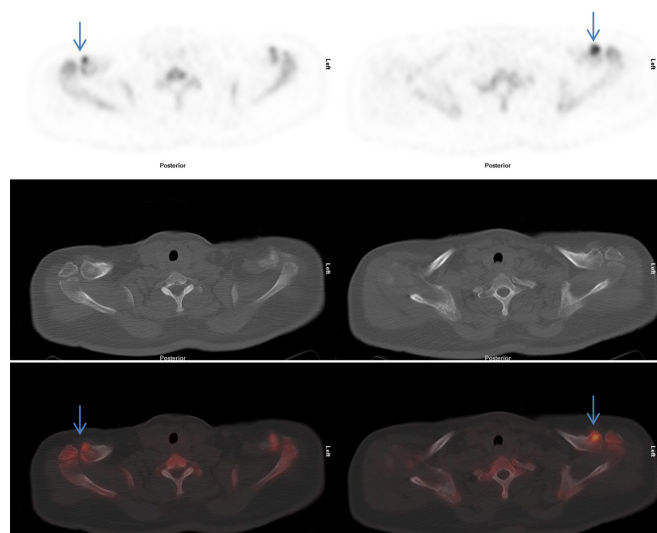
A 63-year-old female with right-sided breast cancer. Axial CT and fused PET-CT images show bilateral OA with no tracer uptake at articulation site. However, there is focal increased tracer uptake noted (arrow) along the left acromioclavicular joints (left more than right). Weight bearing stress radiographs demonstrated left ACJ instability. ACJ, acromio-clavicular joint; OA, os acromiale; PET, positron emission tomography.
